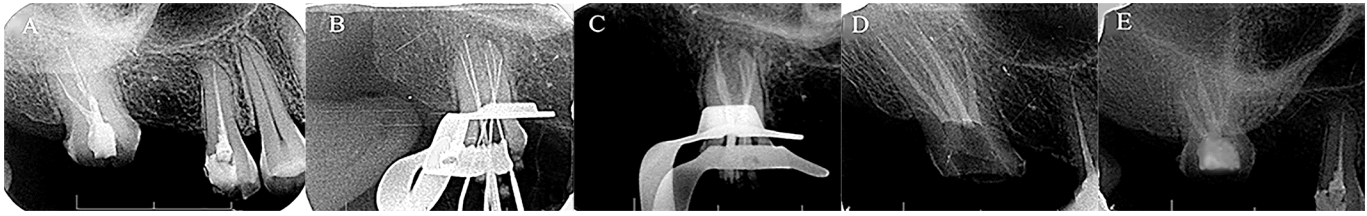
A) A pre-operative periapical radiograph of tooth #17; B and C) The working length and master apical cone periapical radiographs; D) The obturation periapical radiograph; E) One-month follow-up
